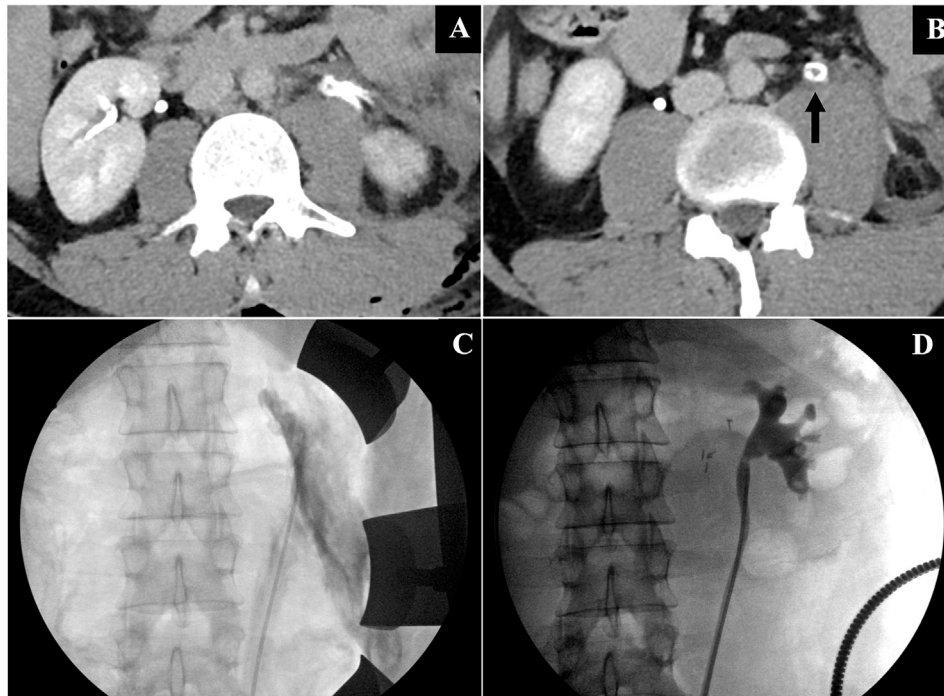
A) Delayed excretory phase CT-scan with contrast material extravasation on the left side and filling defect in the center of the left ureter; B) Circumferential contrast extravasation with “bull’s-eye” sign in the left ureter; C) Initial retrograde ureteropyelogram showing disruption of the UPJ with contrast extravasation; D) Retrograde ureteropyelogram 8 months post-repair showing well-healed ureteropelvic junction.
